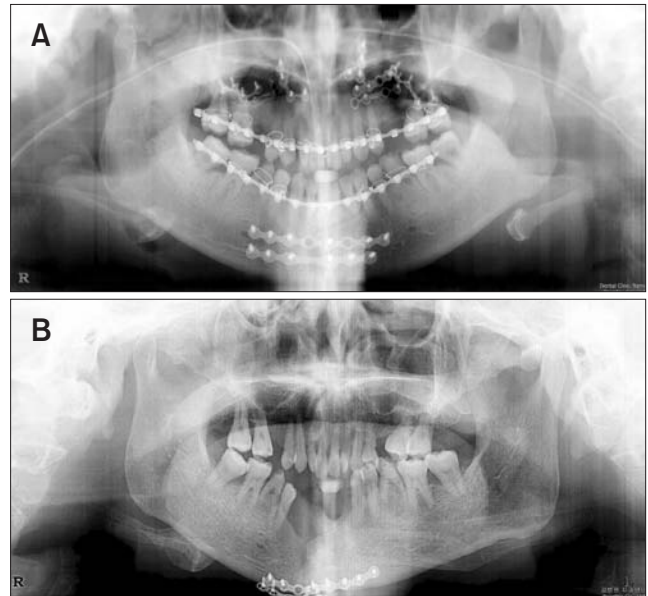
A 44-year-old woman with a facial trauma. (A) Panoramic radiograph at the first visit. (B) Panoramic radiograph of the severely resorbed anterior mandible at 6 months after the re-operation of fractures.
